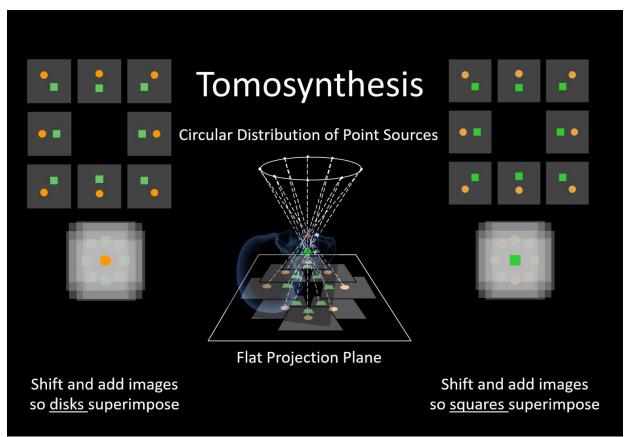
Tomosynthesis geometrical concept. A disc and a square at located within two different coronal planes. Individual projections taken at different angles from a circular x-ray source array arranged at the top left and top right. Projections are shifted and overlapped so that the disc(left) and square on the right are overlapped and objects from different planes are blurred.
